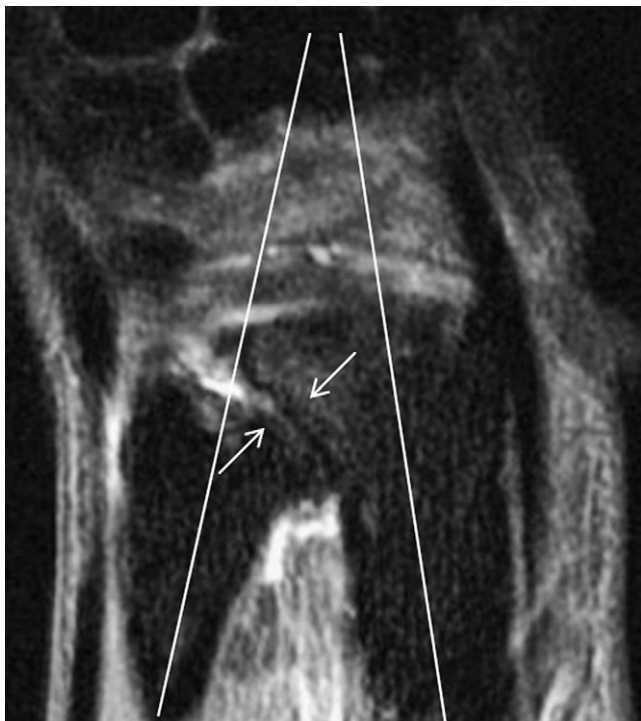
Ulnar impingement syndrome. Coronal short-time inversion recovery magnetic resonance image, demonstrating a short ulna, radioulnar convergence (white lines), and pseudarthrosis between the radius and ulna (white arrows).
